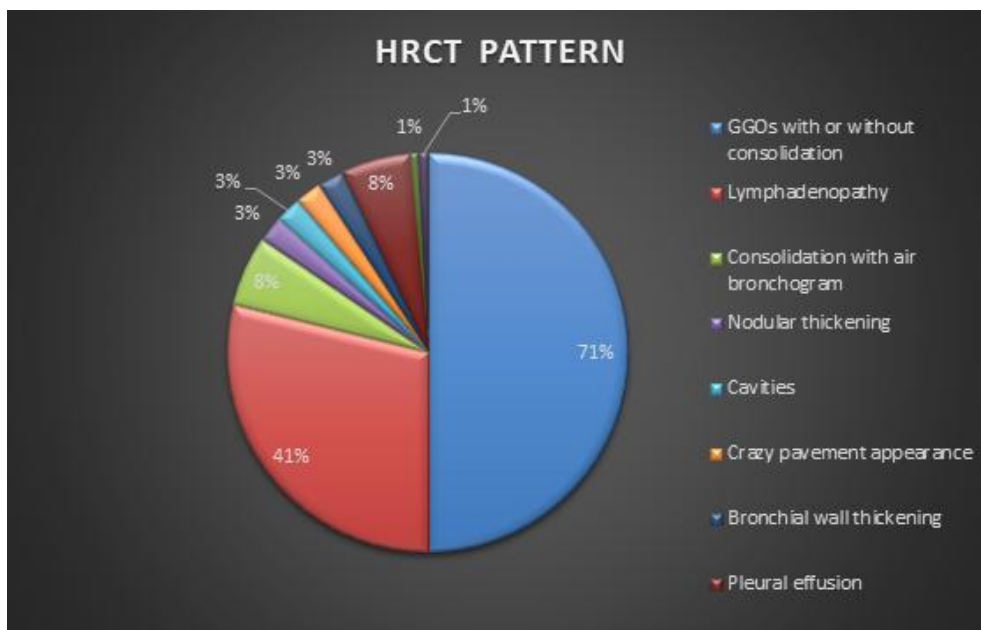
Distribution of HRCT pattern in Covid 19 patients.
